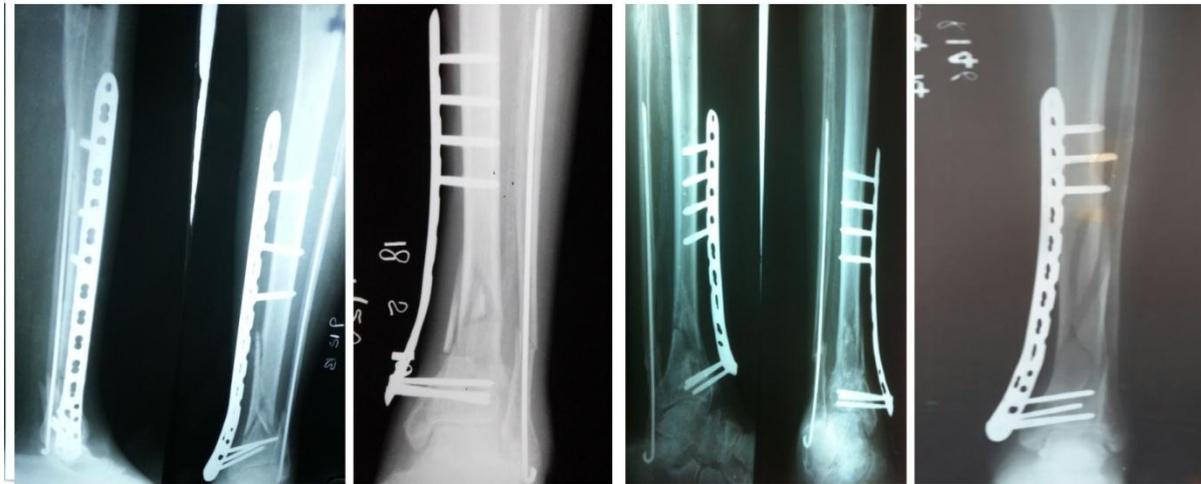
Radiographic outcome of some cases.
